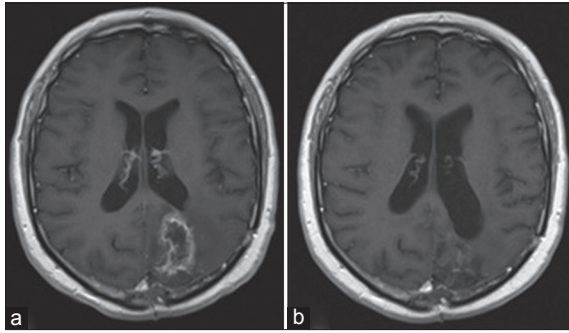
(a) Magnetic resonance imaging 3 months after finishing radiotherapy during temozolomide monotherapy; (b) response after two cycles of fotemustine and bevacizumab treatment
